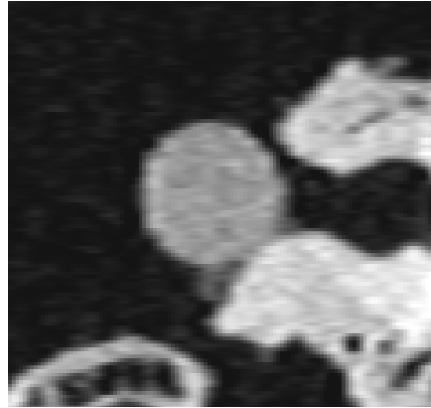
Comparing reconstruction quality of various SRR methods applied to two nearly orthogonal low-resolution CT images (anisotropy factor ≈ 4.5). A representative slice of the HR image and the appropriate LR image of one input data set are shown in the left column.
